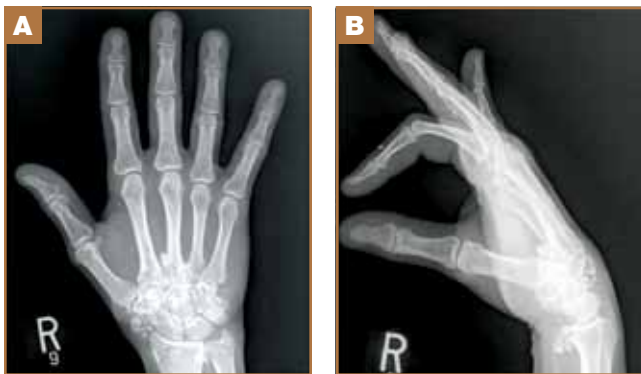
Anteroposterior (A) and lateral (B) radiographs of hand show multiple calcified nodules with extensive wrist and carpal involvement.
